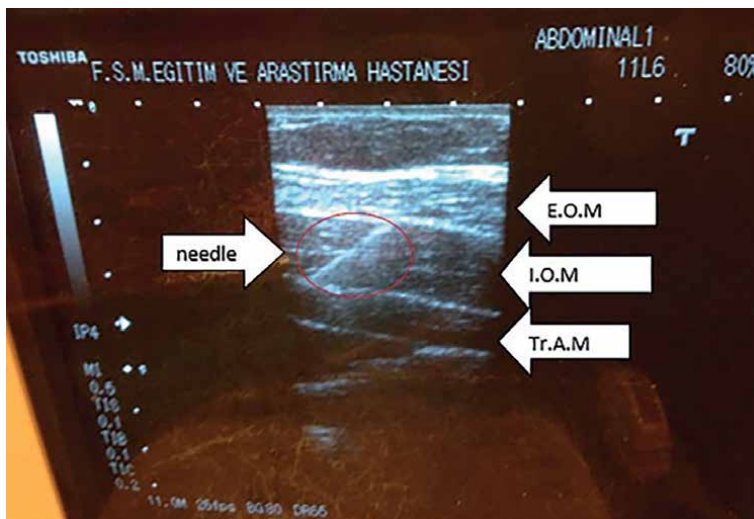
Ultrasound visualization of initial TAP block injection: Needle placement and muscle layer identification.*
